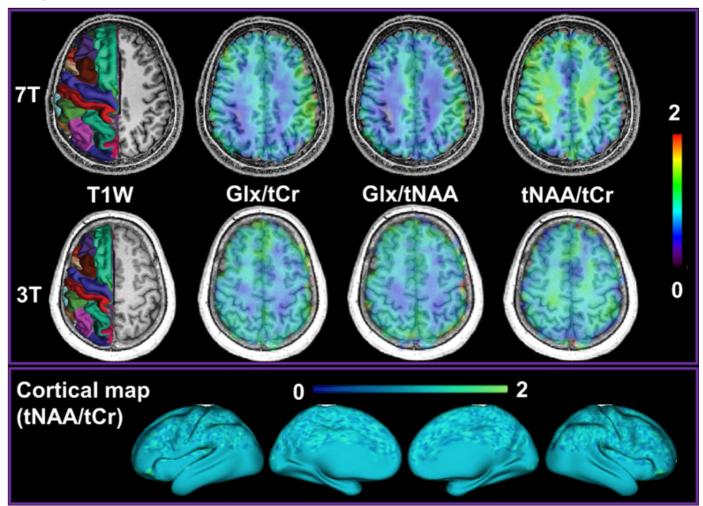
(Top) Metabolic maps of three important metabolites [tNAA = N-acetyl-aspartate (NAA)+ N-acetyl-aspartyl (NAAG); Glx= Glutamate (Glu) + Glutamine (Gln); tCr = Creatine (Cr) + phosphocreatine (PCr) together with anatomical T1-weighted (T1w) images acquired at 7T (top) and 3T (bottom). DKT parcellations are overlayed on the T1w image. (Bottom) The tNAA/tCr map sampled onto the cortical surface. Colour bars indicate relative concentrations.
